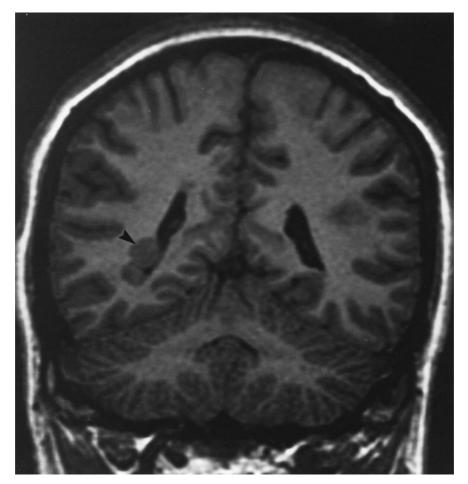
Coronal T_1 -weighted MRI (Ir SPGR) showing nodular subependymal heterotopia in the inferiorlateral wall of the right lateral ventricle (arrow head).
